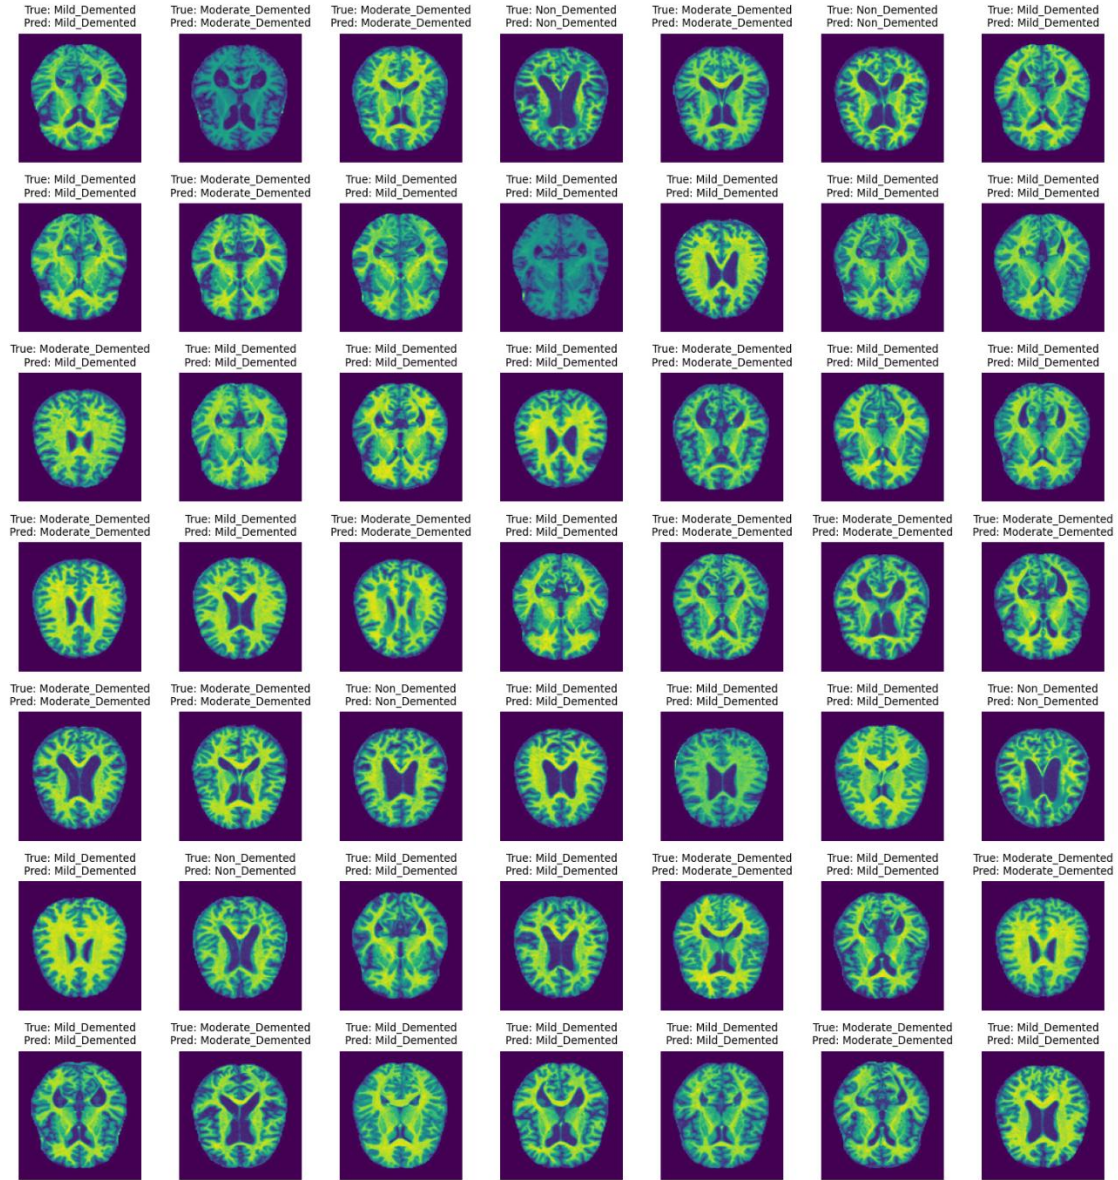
Visualization of True and Predicted Labels for Alzheimer's MRI Classification
